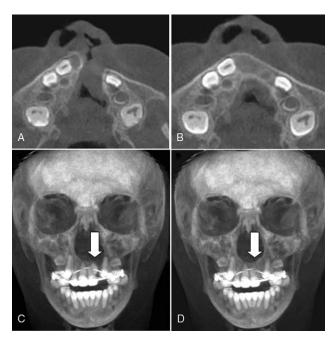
A cone beam CT scan of a patient with left cleft lip and palate. A. Preoperative axial imaging showing alveolar defect (arrow). B. Postoperative axial imaging 6 months after GPP with BMP-2 showing bone healing and mineralization across the previous bone defect. C. Preoperative frontal imaging showing left alveolar defect (arrow). D. Postoperative frontal imaging 6 months after GPP with BMP-2 showing bone healing and mineralization across the previous bone defect. CT, computed tomography; BMP, bone morphogenetic protein; GPP, gingivoperiosteoplasty.
